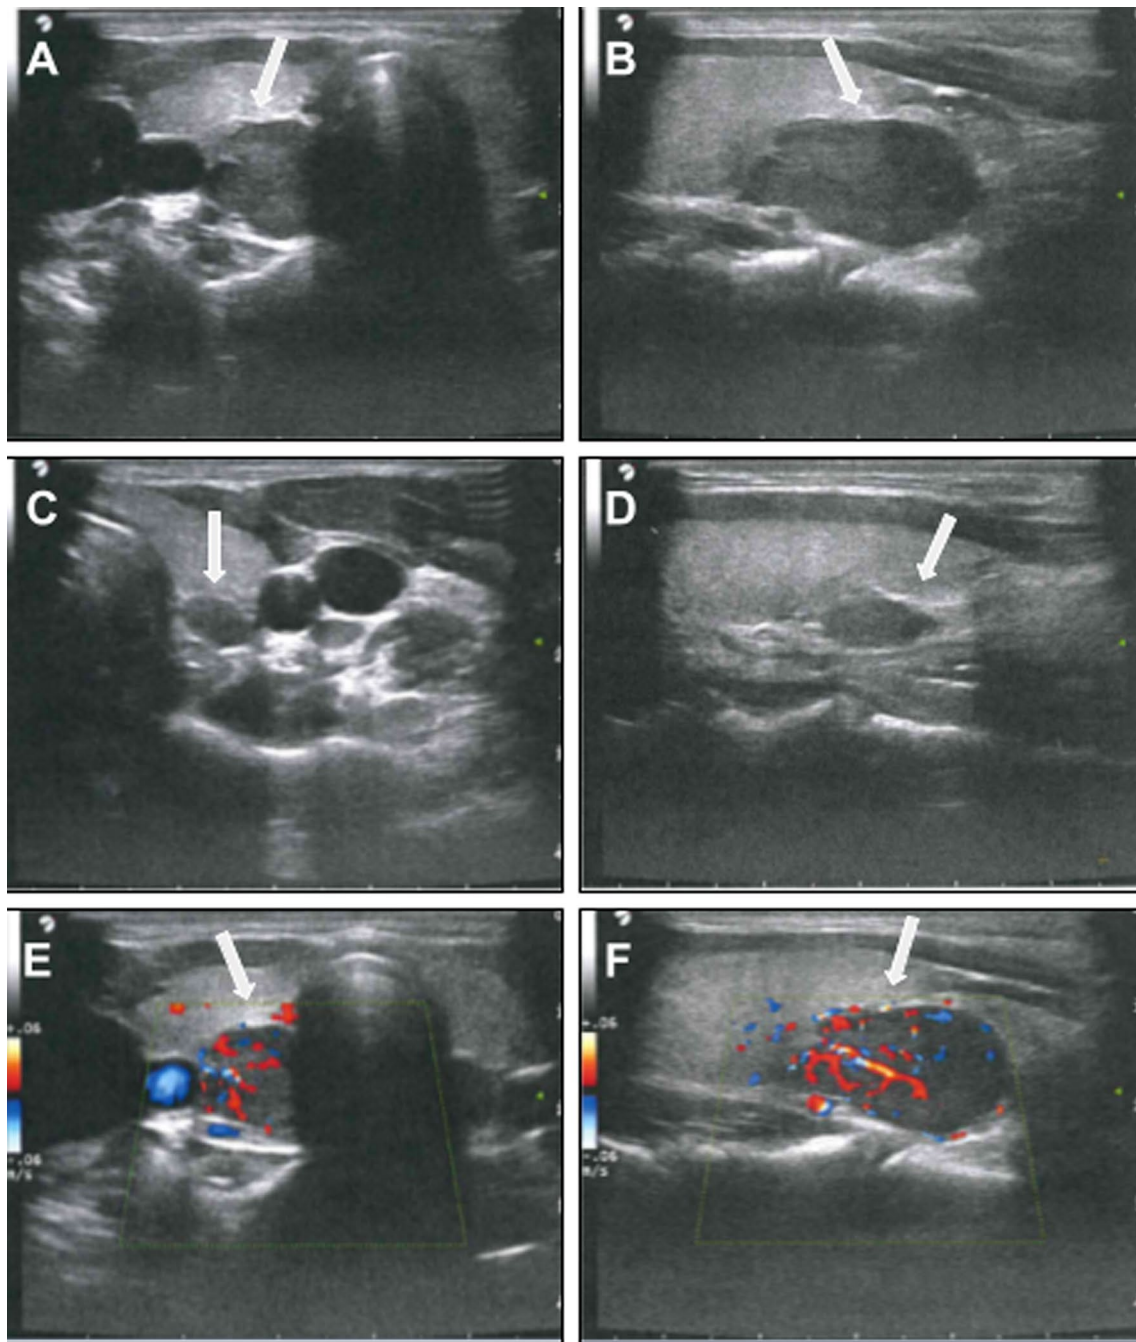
Ultrasound image of two enlarged parathyroid glands in a 26-year-old woman with MEN1. The tumors (arrows) are located at the lower right pole of the thyroid (A, transverse view; B, longitudinal view), and at the lower left pole of the thyroid (C, transverse
